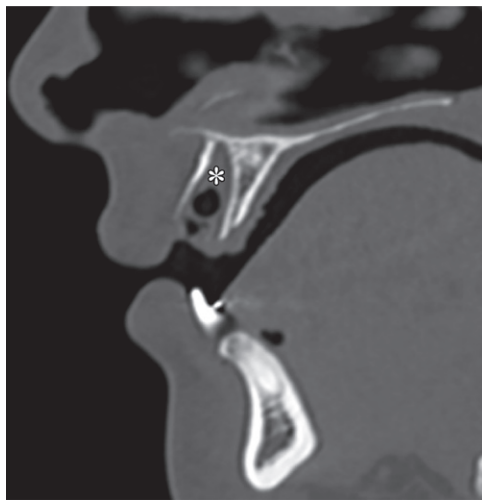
Dental avulsion. Sagittal CT image (bone window) shows an empty alveolar socket (*).
